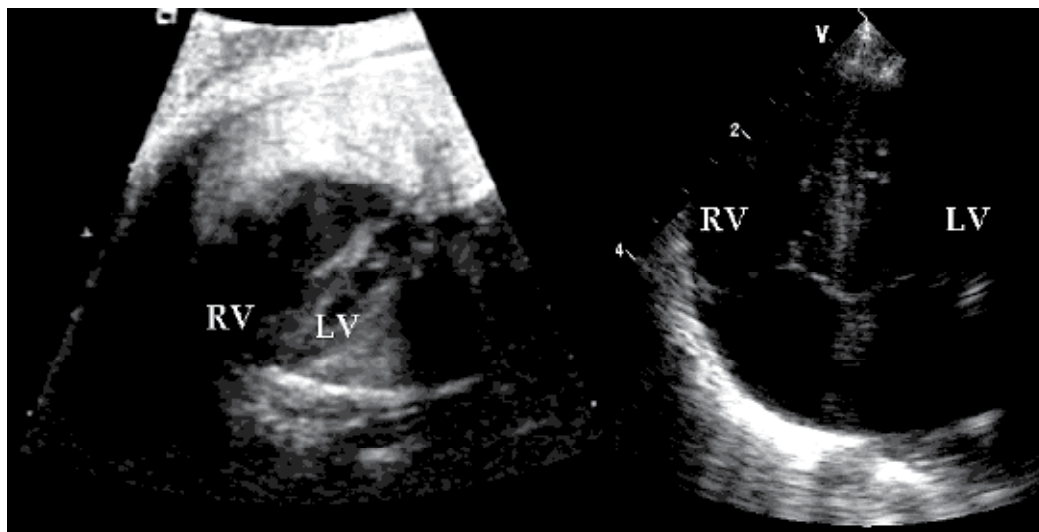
Four chamber echocardiographic views demonstrating small left ventricle (due to restrictive atrial flow) in foetus (left) and unfolding of the left ventricle 4 hours after birth (right).
